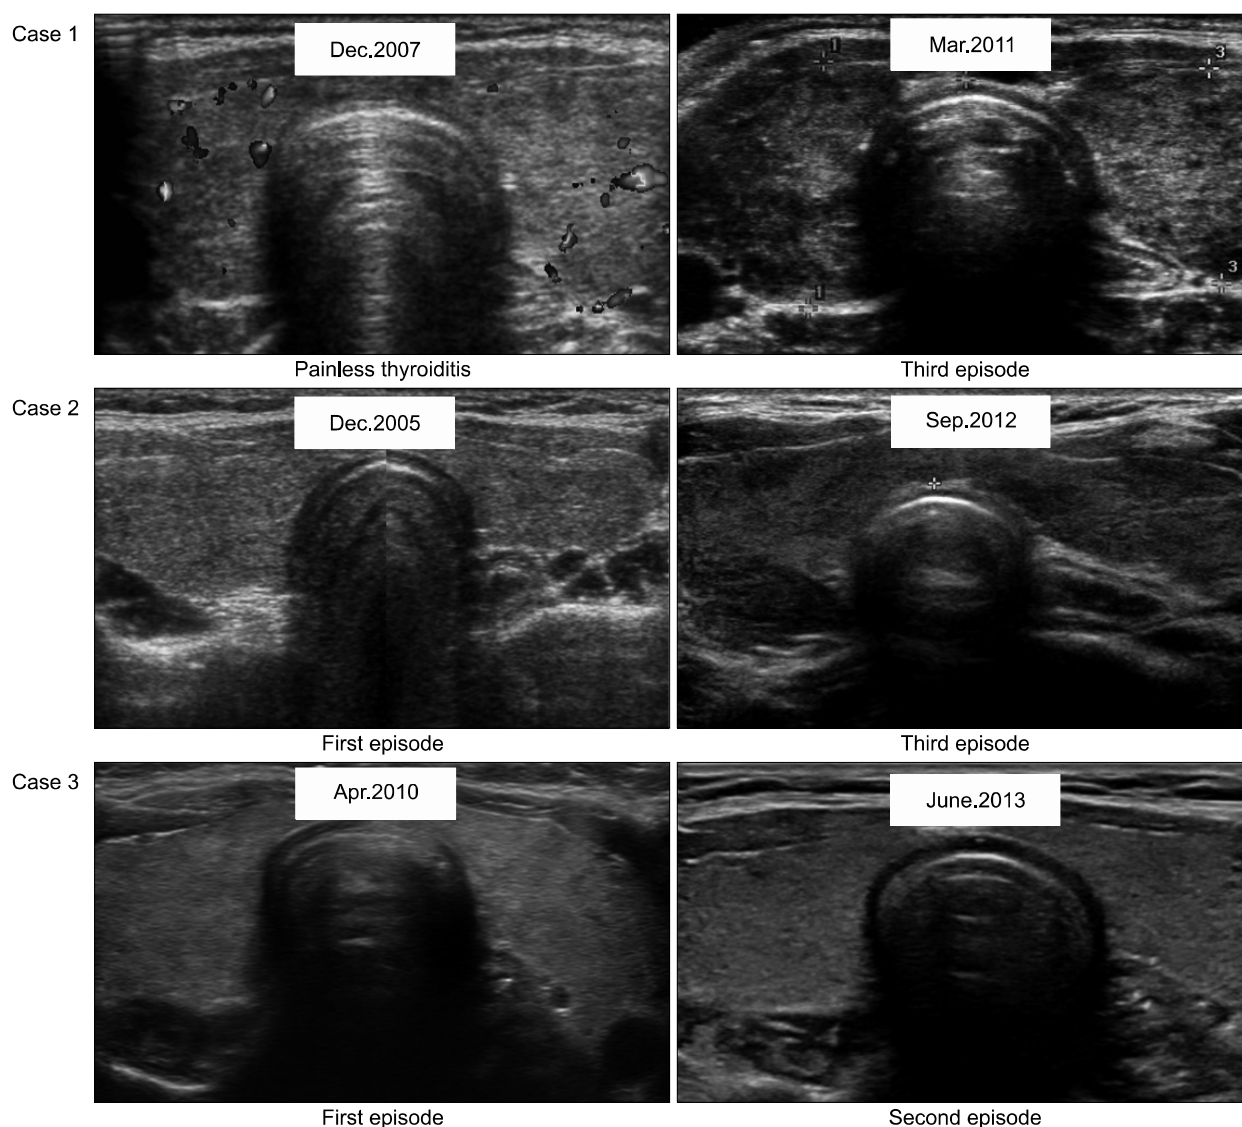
Thyroid ultrasonographic findings of painless thyroiditis episodes in the three cases.
